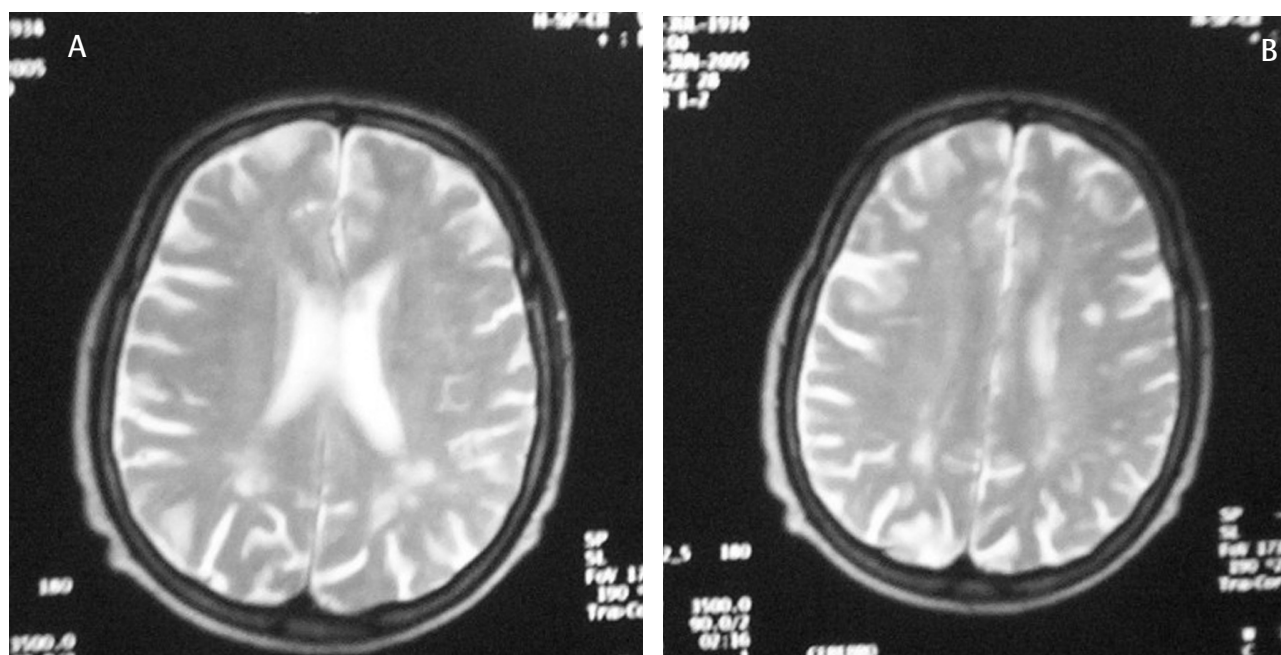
MRI in T2. The left subcortical lacunar lesion (A) and leukoaraiosis lesions of the posterior border territories (B).
